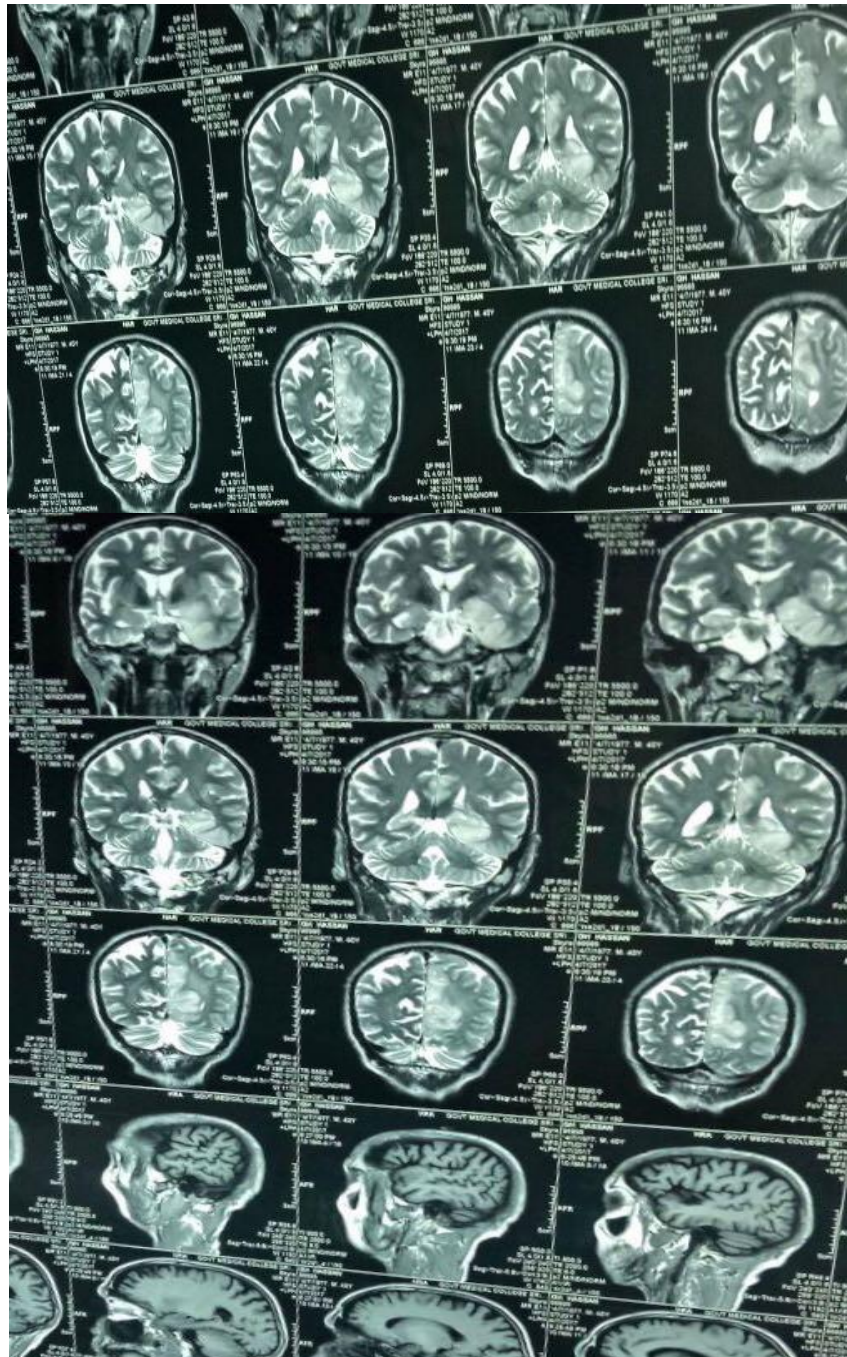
showing initial MRI of patient with T2WI show hyper intensity involving the left medial temporal lobe and thalamus with mild mass effect on the ipsilateral lateral ventricle.
